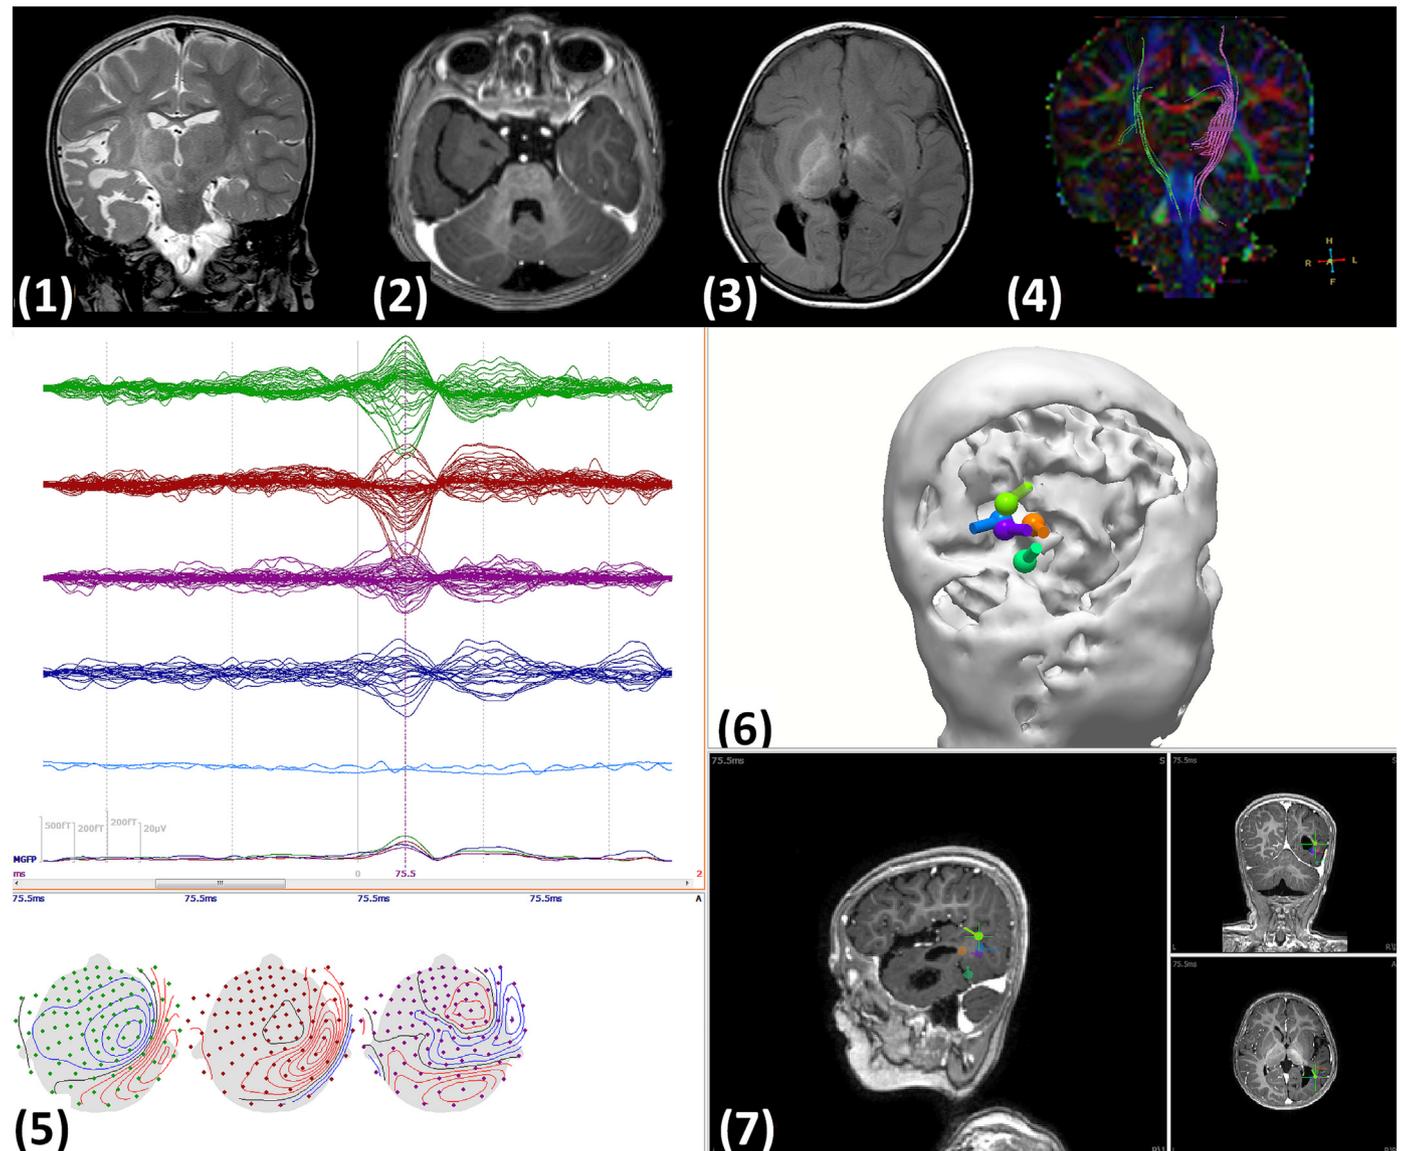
(1) Coronal T2W image — shows a grossly distorted right temporal lobe with a large fissure extending from the inferior surface to the medial temporal lobe. Large complex cortical dysplasia involving the right medial temporal lobe with dysplastic parenchyma separated from rest of the temporal lobe by deep collateral sulcus which bifurcates the anterior part of the temporal lobe, (2) gadolinium contrast axial images — large deep collateral sulcus dividing medial and the lateral temporal lobes, (3) T2W FLAIR axial — hemispheric asymmetry, exvacuo dilatation of the ipsilateral lateral ventricle, hyper-intensity of bilateral basal ganglia and involvement of the insular region and internal capsule, (4) DTI tractography shows grossly reduced thickness of the corticospinal tracts (right CST — green, left CST — pink), (5) shows the butterfly plots of the averaged spikes in magnetometers and x and y — planar gradiometers and simultaneous scalp EEG channels, (6 & 7) shows the dipoles, obtained from the ECD modeling of the averaged IEDs, on patient's rendered structural MRI and on the planar sections. The dipoles localized to the posterior margins of the dysplasia.
